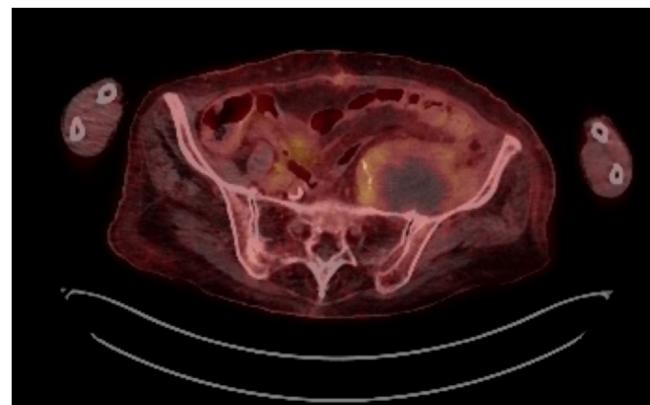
Positron emission tomography CT (PET-CT) was performed with a heterogeneous density mass of the left pelvis and left flank identified.
